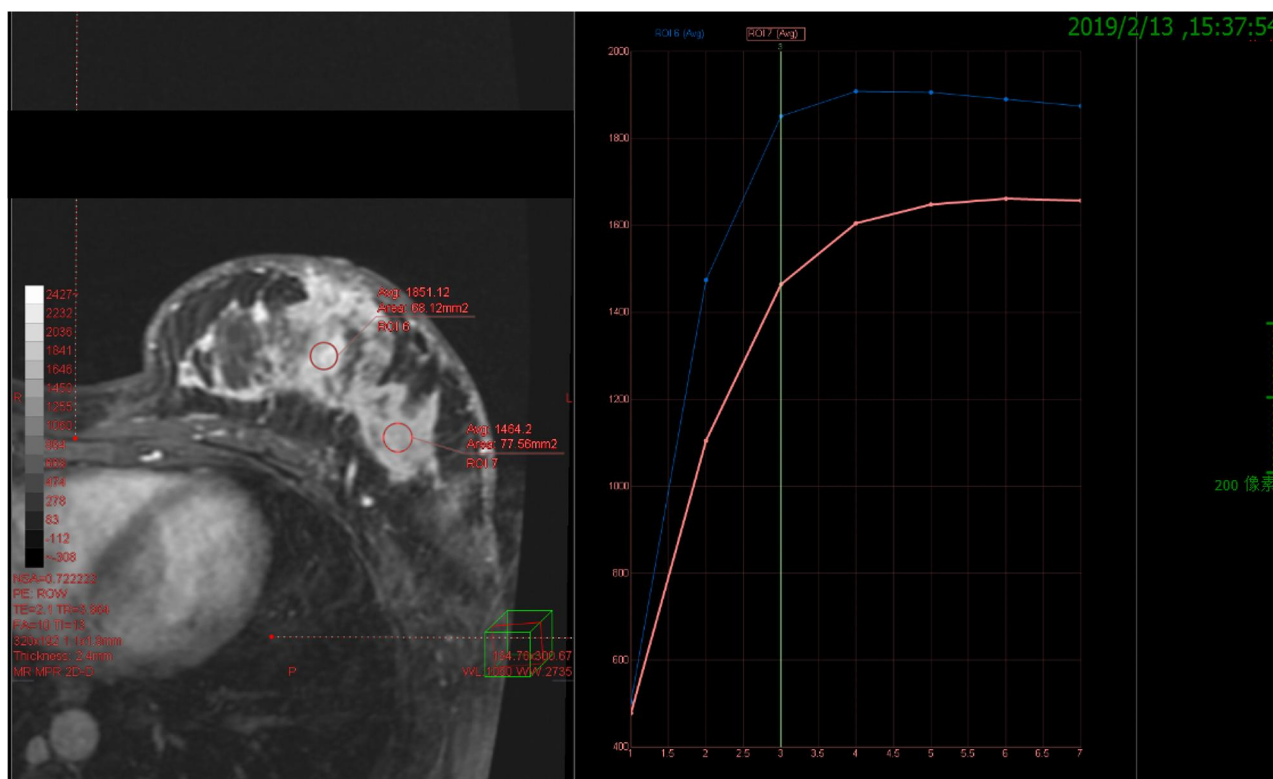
Breast MRI (2019.02.13). Notes: The time-intensity curve (TIC) shows a platform-type or outflow-type curve, and the Apparent Diffusion Coefficient (ADC) value was approximately $0.95 \times 10^{-3} \text{ mm}^2/\text{s}$, suggesting a malignant tumor (BI-RADS.6).
